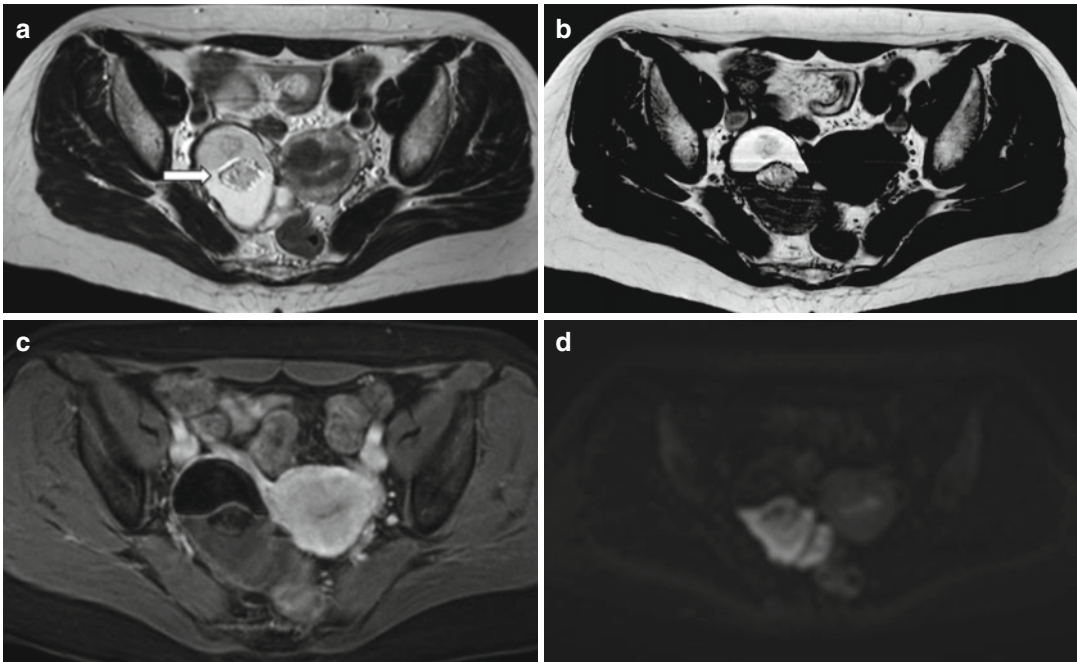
Mature teratoma. A 47-year-old woman with ovarian enlargement on US and normal CA125. Pelvic MRI shows a right-sided complex adnexal mass. There is a fluid–fluid level, as depicted on axial T2-weighted image (TR:4361, TE:80; a) with hyperintense material on the top on axial T1-weighted image (TR:519, TE:10; b), the signal of which is suppressed on fat-saturated T1-weighted
